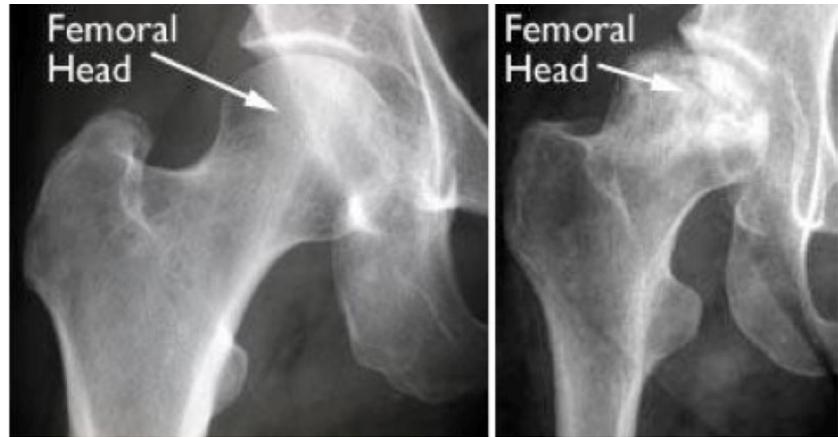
Left, radiograph of a healthy hip joint. Right, radiograph of a hip joint where the osteonecrosis has progressed to collapse of the femoral head.
